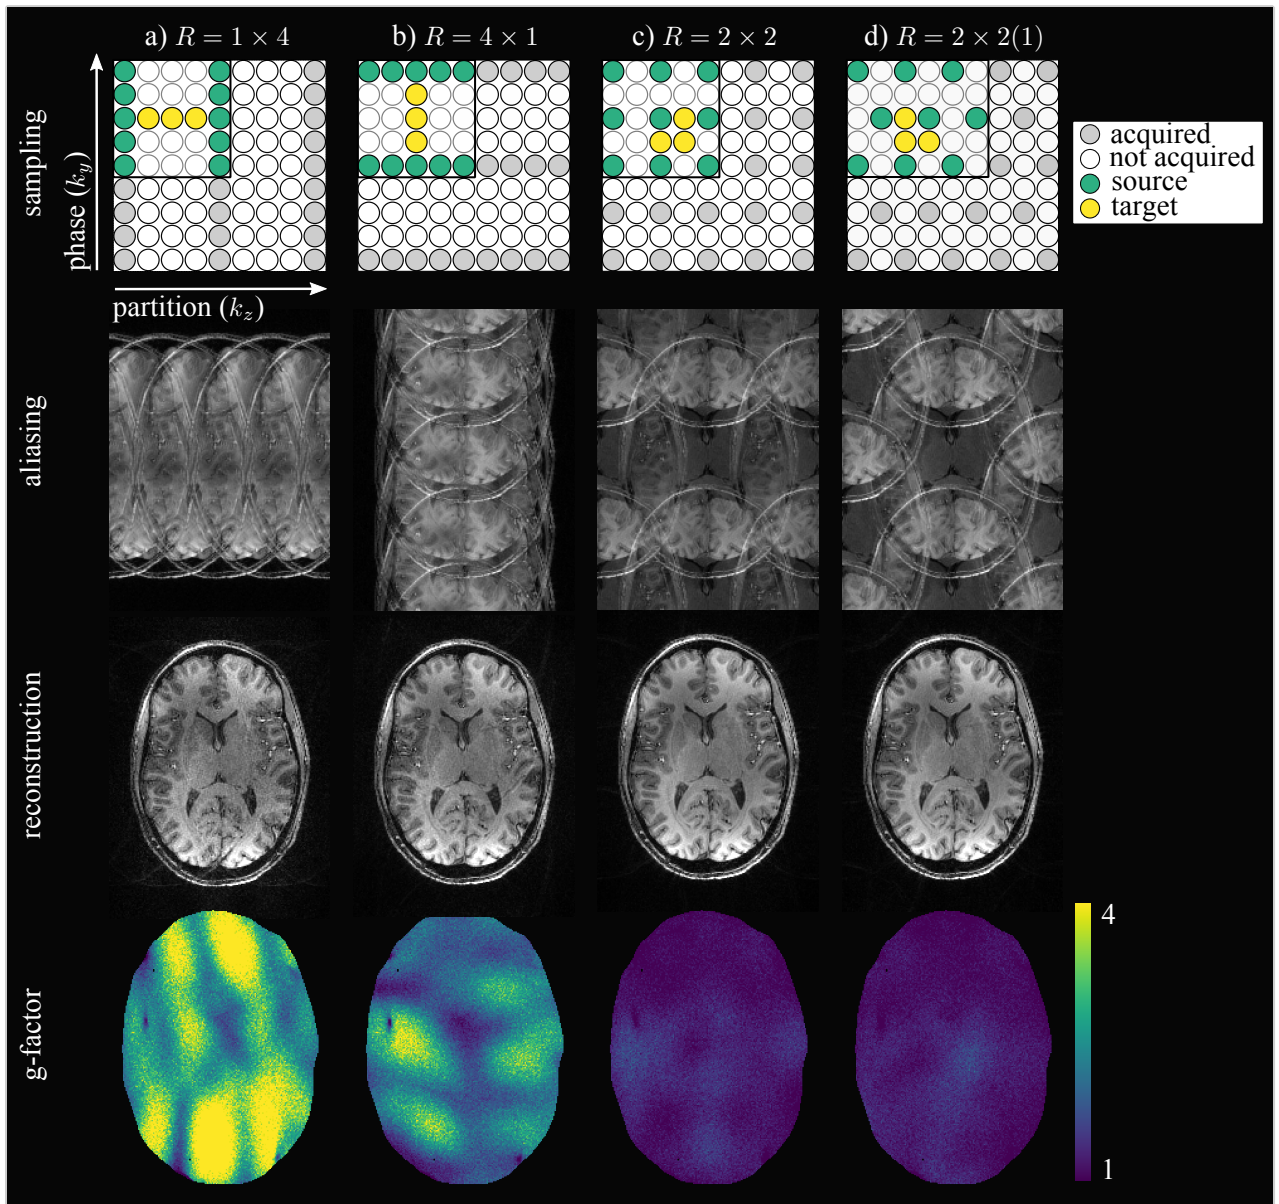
Different  $k$ -space sampling schemes for 4-fold accelerated 3D MRI. For simplicity, the fully sampled readout direction is omitted. For a subsampling along partition or phase encoding direction ( $R = 1 \times 4$  or  $R = 4 \times 1$ ), the aliasing only appears along this direction. If the dataset is reduced in both directions ( $R = 2 \times 2$ ), the aliasing is spread more efficiently over the image. The parallel imaging reconstruction (here GRAPPA) strongly benefits from the coil sensitivity variations along both directions. Image artifacts and the  $g$ -factor are clearly reduced. 2D CAIPIRINHA sampling with shift  $\Delta = 1$  ( $R = 2 \times 2(1)$ ) further modifies the appearance of aliasing. This results in a further small  $g$ -factor decrease. The example reconstruction kernels chosen for the GRAPPA reconstruction are depicted in the sampling scheme (top row) with source and target points marked in green and yellow, respectively.
